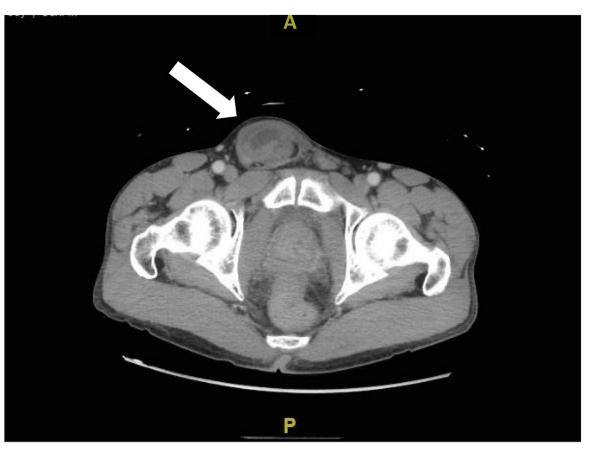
CT showing an incarcerated right inguinal hernia with small bowel in the right groin/hernia sac.
